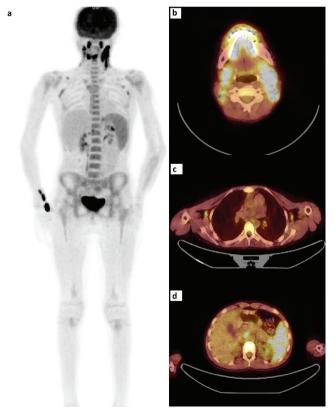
Increased ¹⁸F-fluorodeoxyglucose (FDG) uptake in the cervical, axillary lymph nodes, spleen, and bone marrow in the patient on maximum intensity projection positron emission tomography/computed tomography image (a); bilateral cervical and axillary lymph nodes with increased ¹⁸F-FDG uptake (b, c); intraabdominal lymph node with increased ¹⁸F-FDG uptake and intense ¹⁸F-FDG uptake in the spleen (d)
